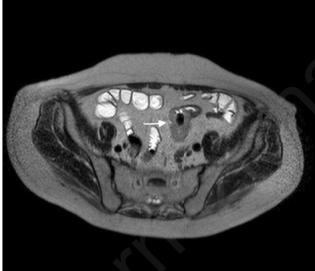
Entero-MRI findings showing a long stenosis (arrows) of proximal jejunum.
